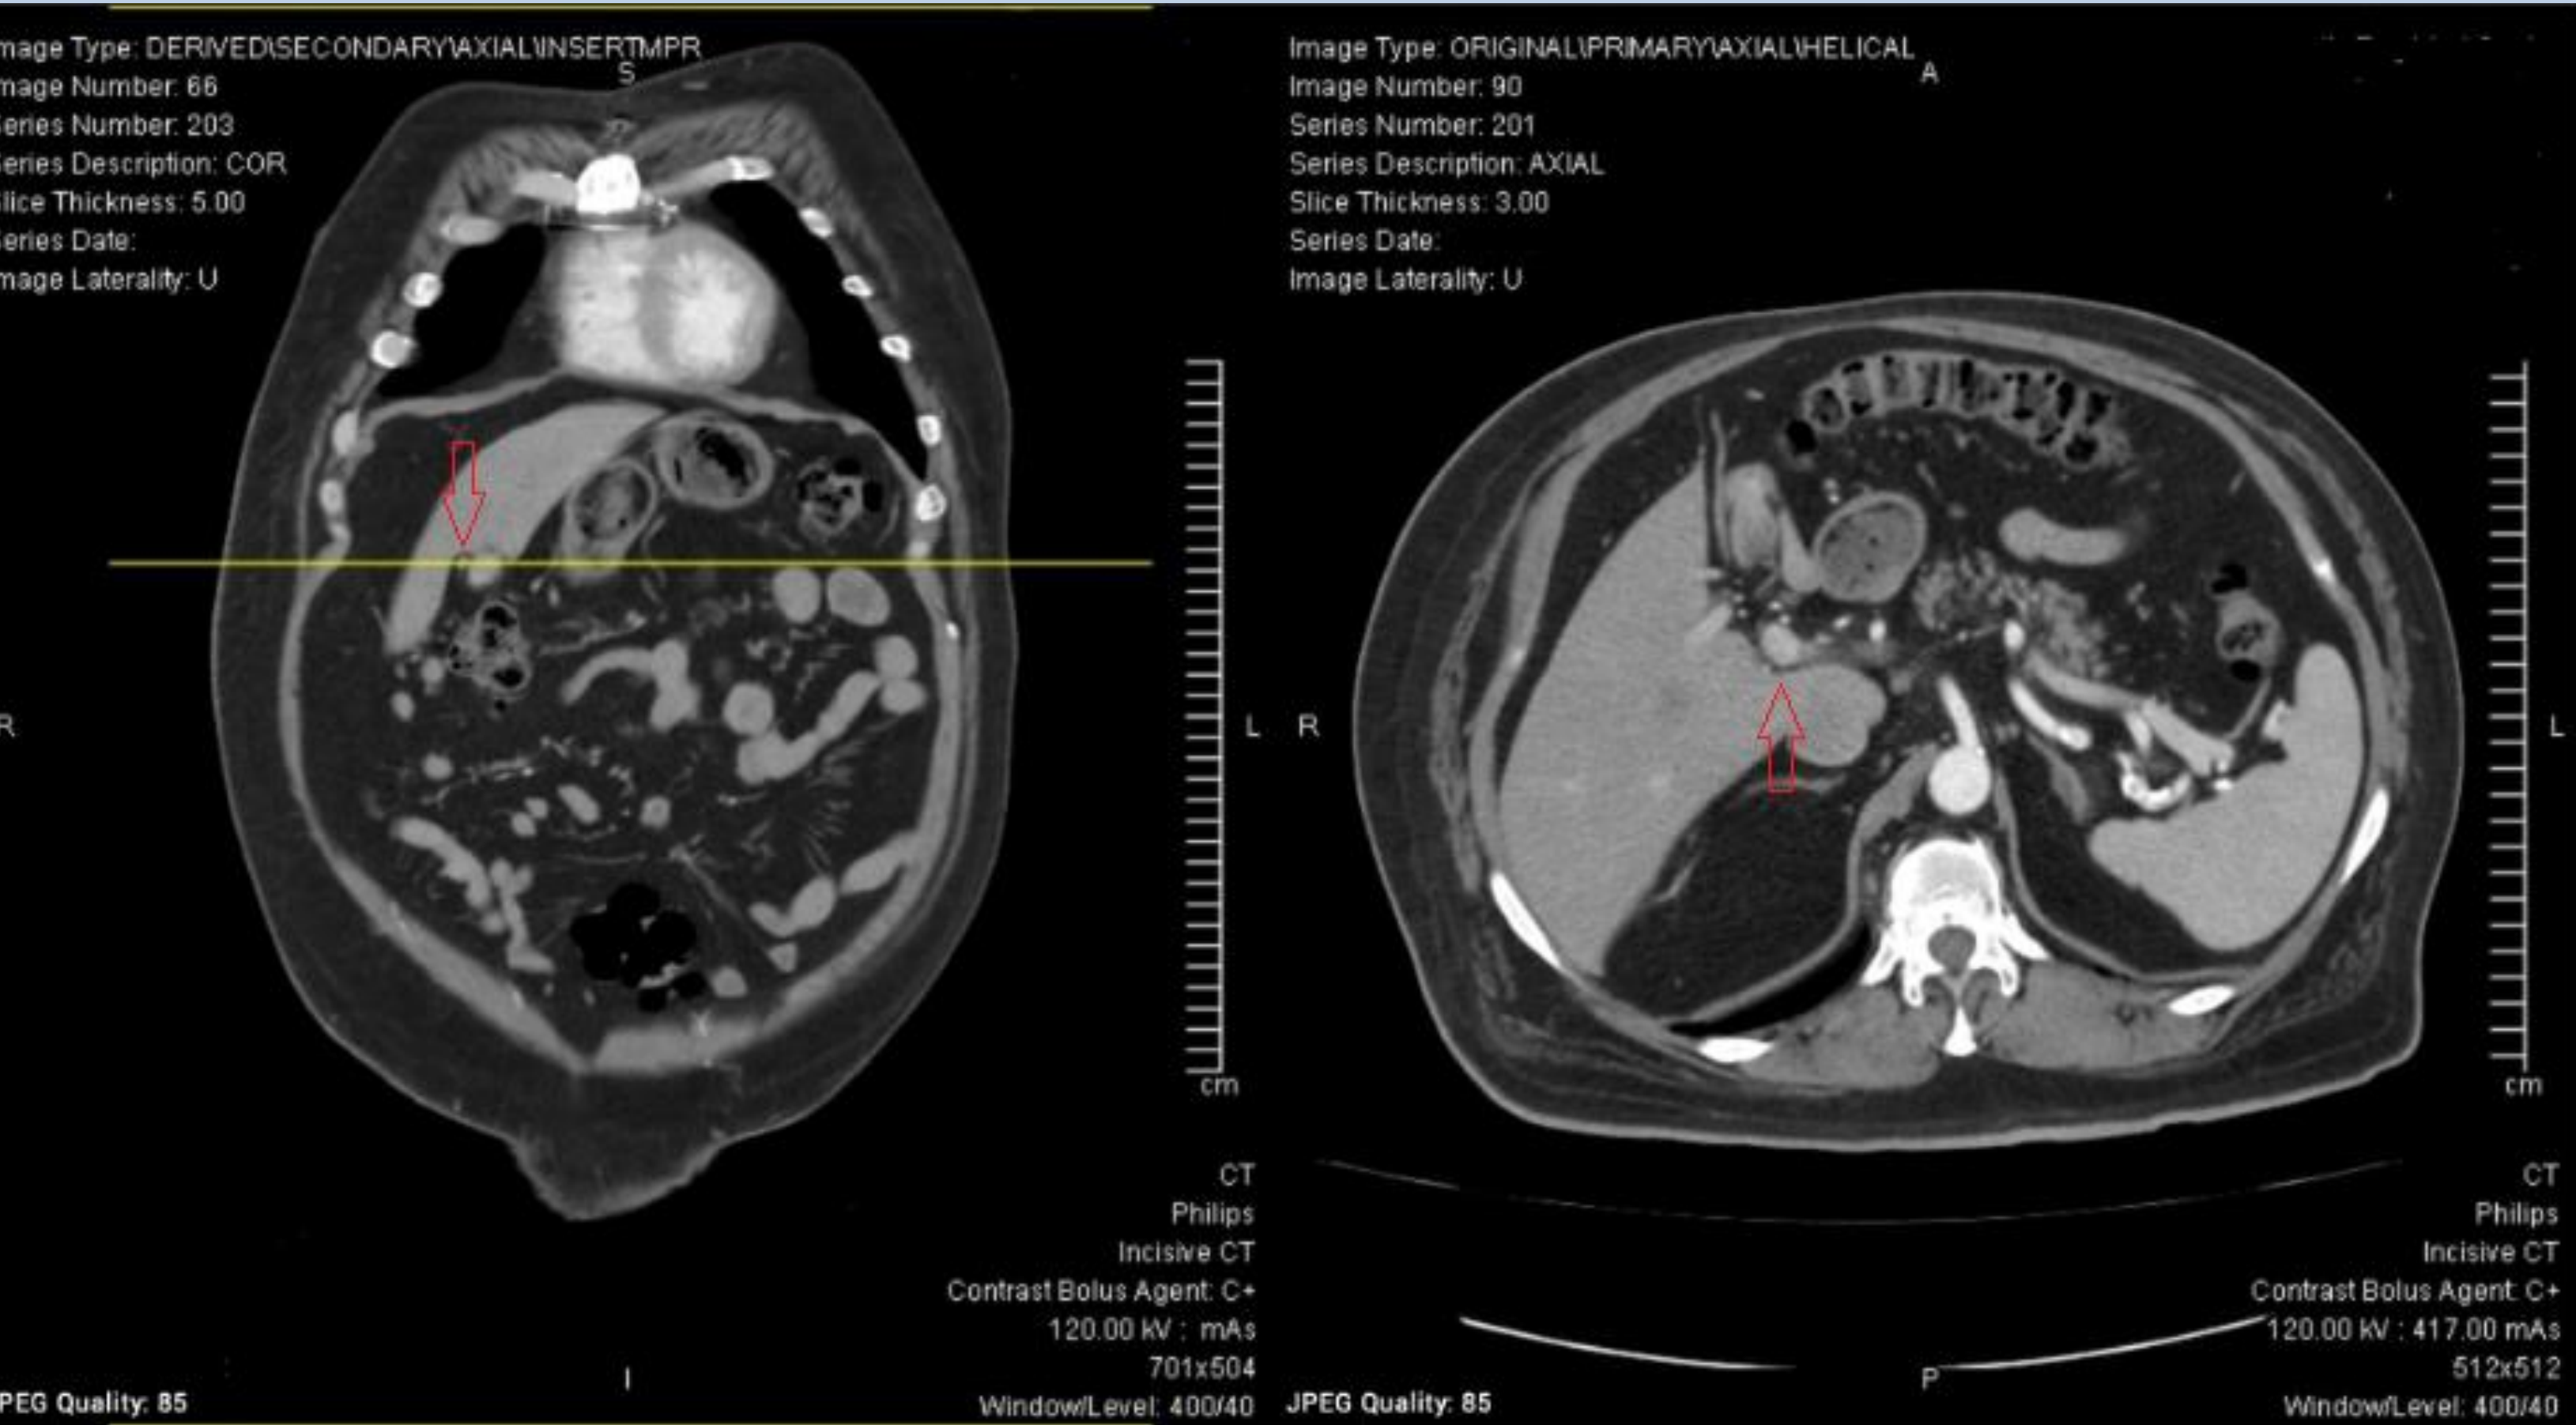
CT demonstrating left-sided gallbladder and adherent portal vein.
